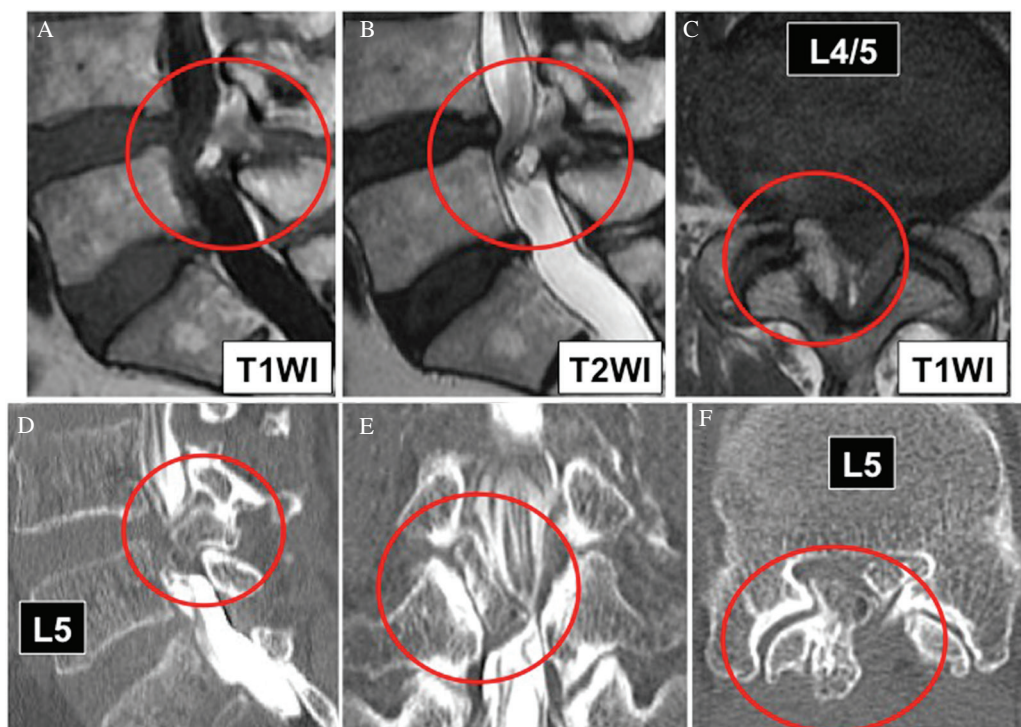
(A–C) Magnetic resonance imaging scans for case 1. (A) T1WI sagittal view. (B) T2WI sagittal view. (C) T1WI axial view. A mass arising from the lamina of L4 presented as a hyperintense area on both T1WI and T2WI and was covered by a lesion that was hypointense on both T1WI and T2WI (red circle). (D–F) Computed tomographic myelogram. (D) Sagittal view, (E) coronal view, (F) axial view. Osseous tumorous prominence can be seen arising from the right inferior articular process of L4 and compressing the dura mater (red circle). The cortex and medullary cavity are continuous with the bony stalk and the center of the lesion.
